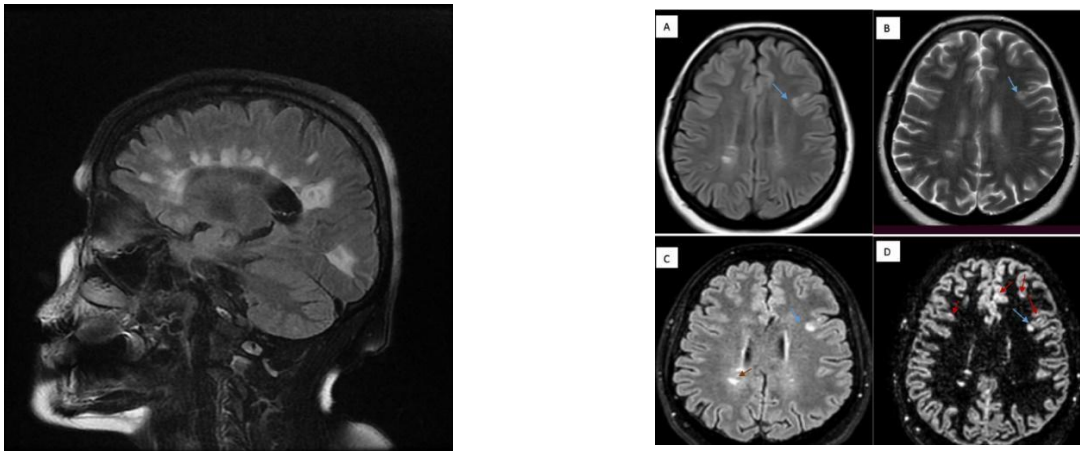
Gadolinium-enhanced MRI Brain showing classical “Dawson’s fingers pattern”
